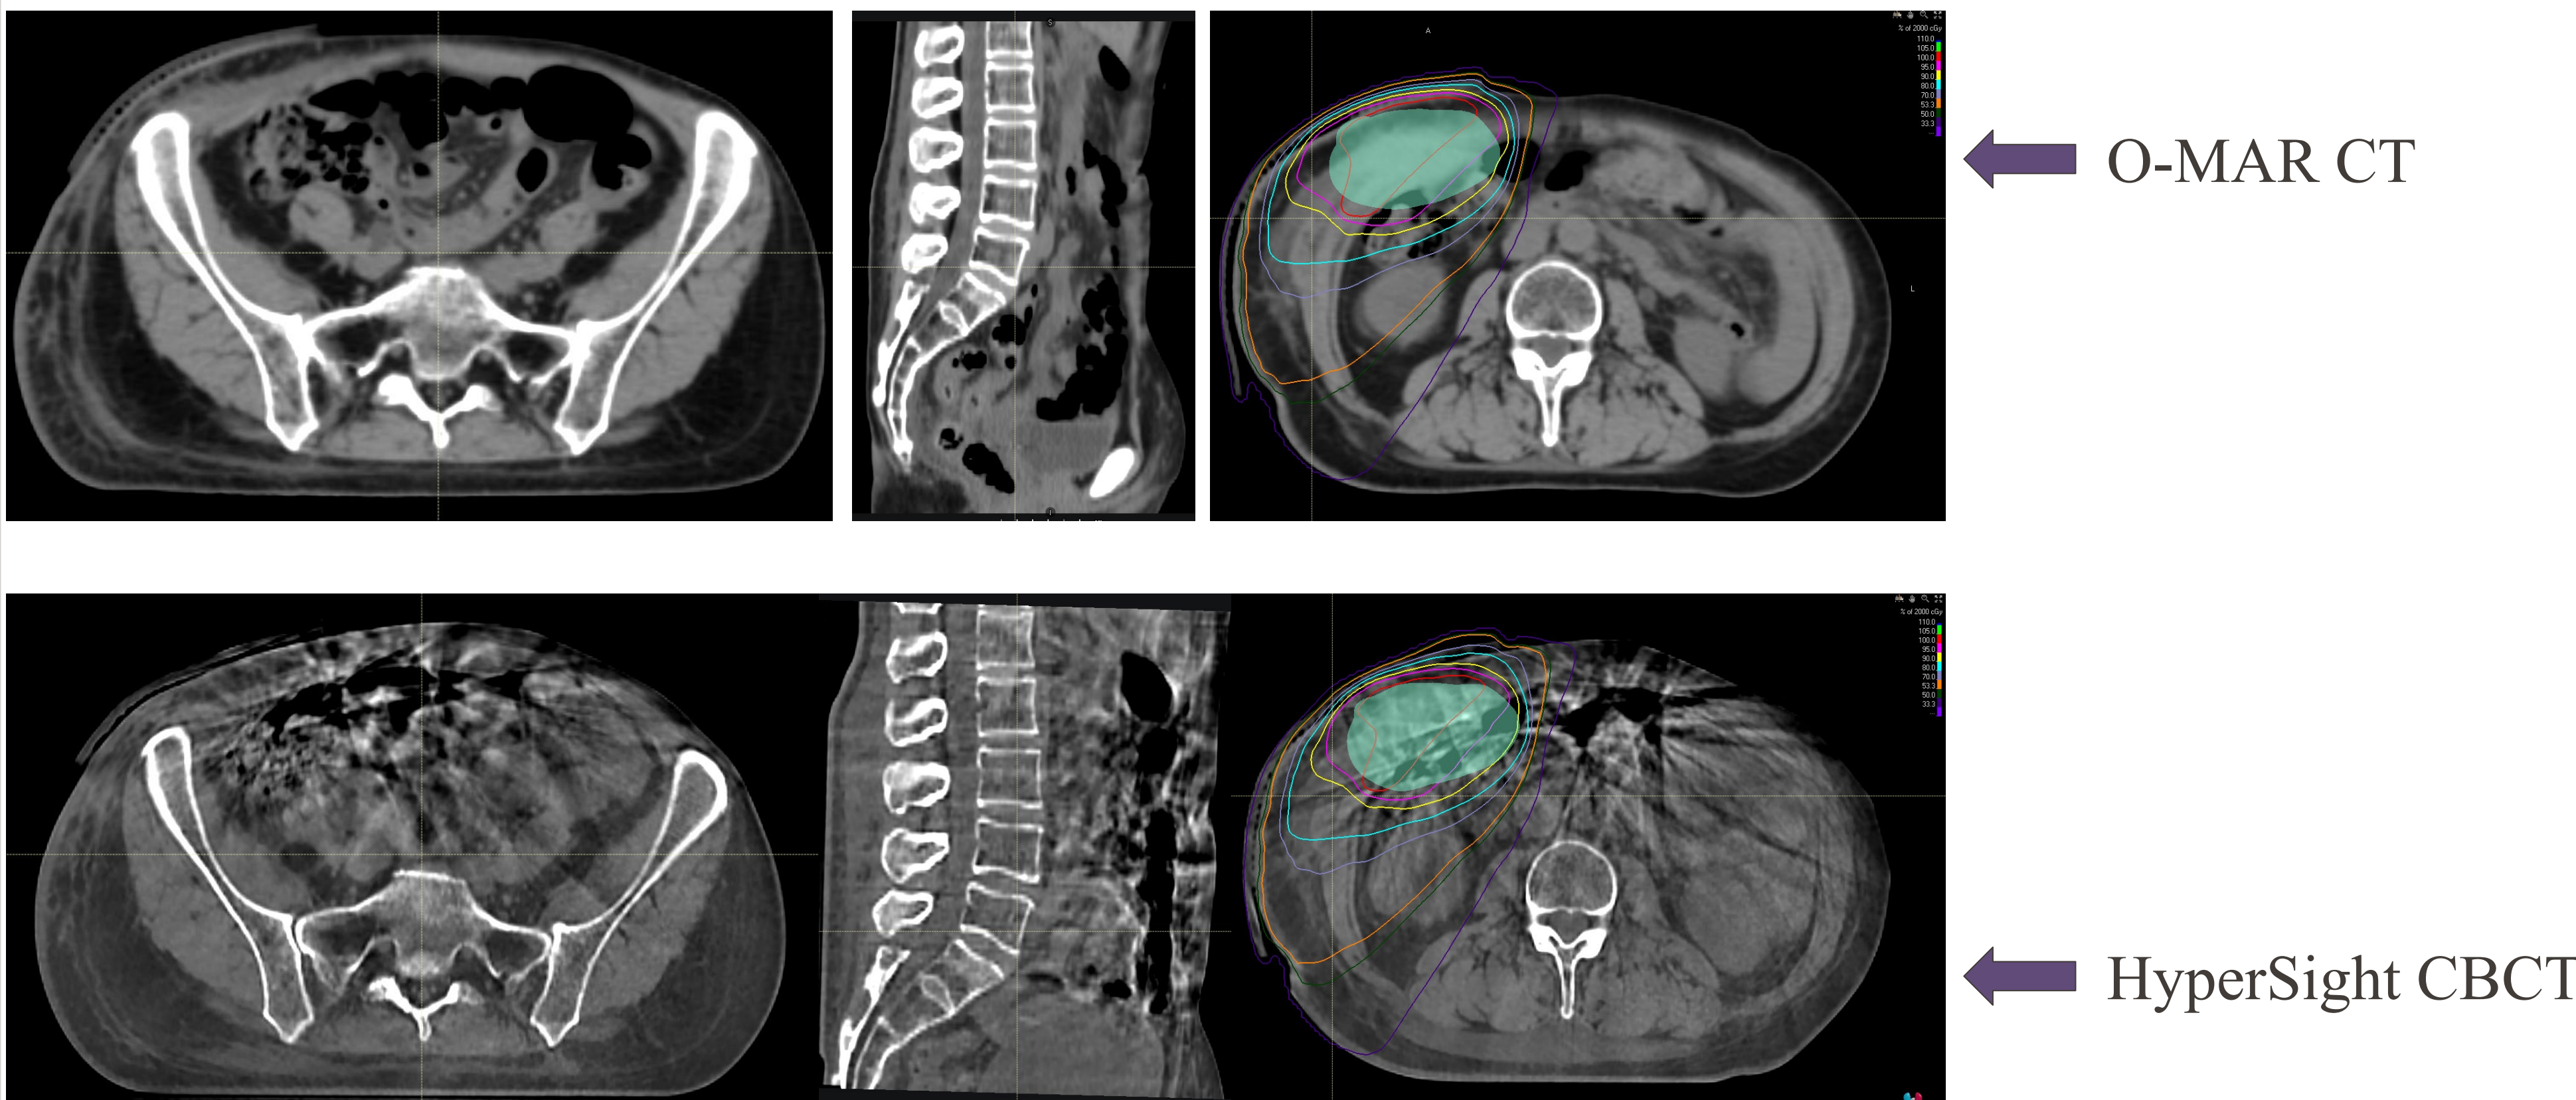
Dose calculation accuracy on CBCT with extensive artifacts. The dose distribution achieved a gamma pass rate of 95.1% using 2 mm/2% criteria.
